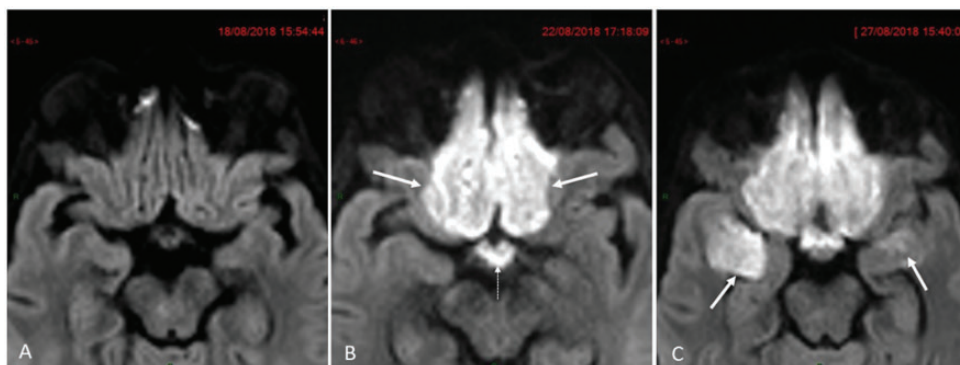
Transverse diffusion-weighted (DW) magnified images in similar slice location focused on olfactory neocortical and paleocortical projection areas. (a) Unremarkable initial examination. (b) Follow-up examination four days later reveals symmetrical cytotoxic edema within primary neocortical olfactory projection areas (arrows) together with hypothalamic-optic tract (dotted arrow). (c) Repeat MRI nine days later reveals additional involvement of both temporal amygdala (arrows) which are one of the paleocortical olfactory projection areas.
